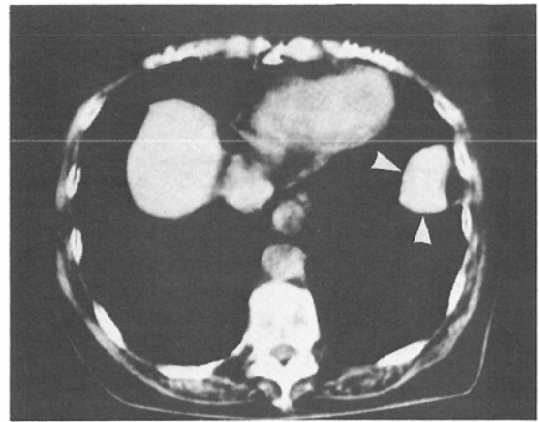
CT scan. The mass bulging into the left hemithorax (arrowheads).
